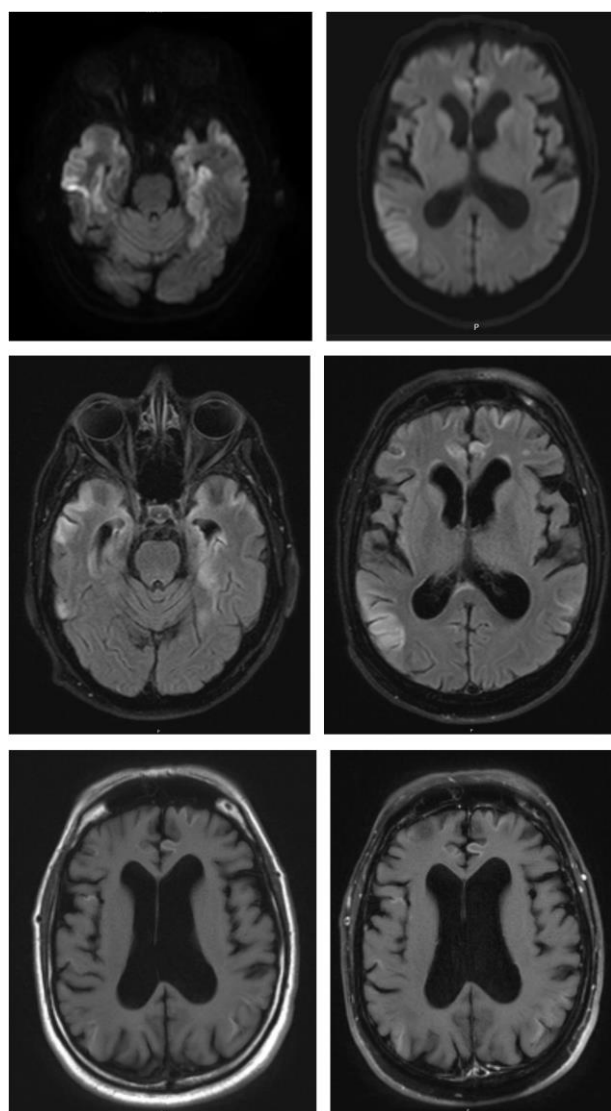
Figure depicting MRI with cortical diffusion restriction in multiple areas of the brain (row 1) as well as FLAIR hyperintensities in similar brain regions (row 2) and intrinsic T1 hyperintensities (row 3 image 1) without contrast enhancement (row 3 image 2).
